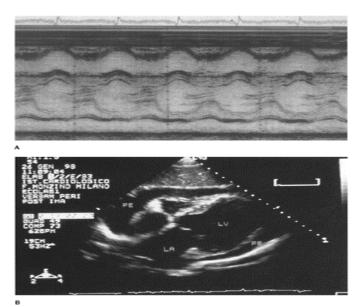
M-mode (A), subcostal four-chamber (B), parasternal short-axis (C), and posterior view (from a back transducer location) (D) of patients with pericardial effusion. The posterior view allows us to demonstrate the association with a left pleural effusion. PE: pericardial effusion; LV: left ventricle; RV: right ventricle; LA: left atrium; Ao: aorta.
